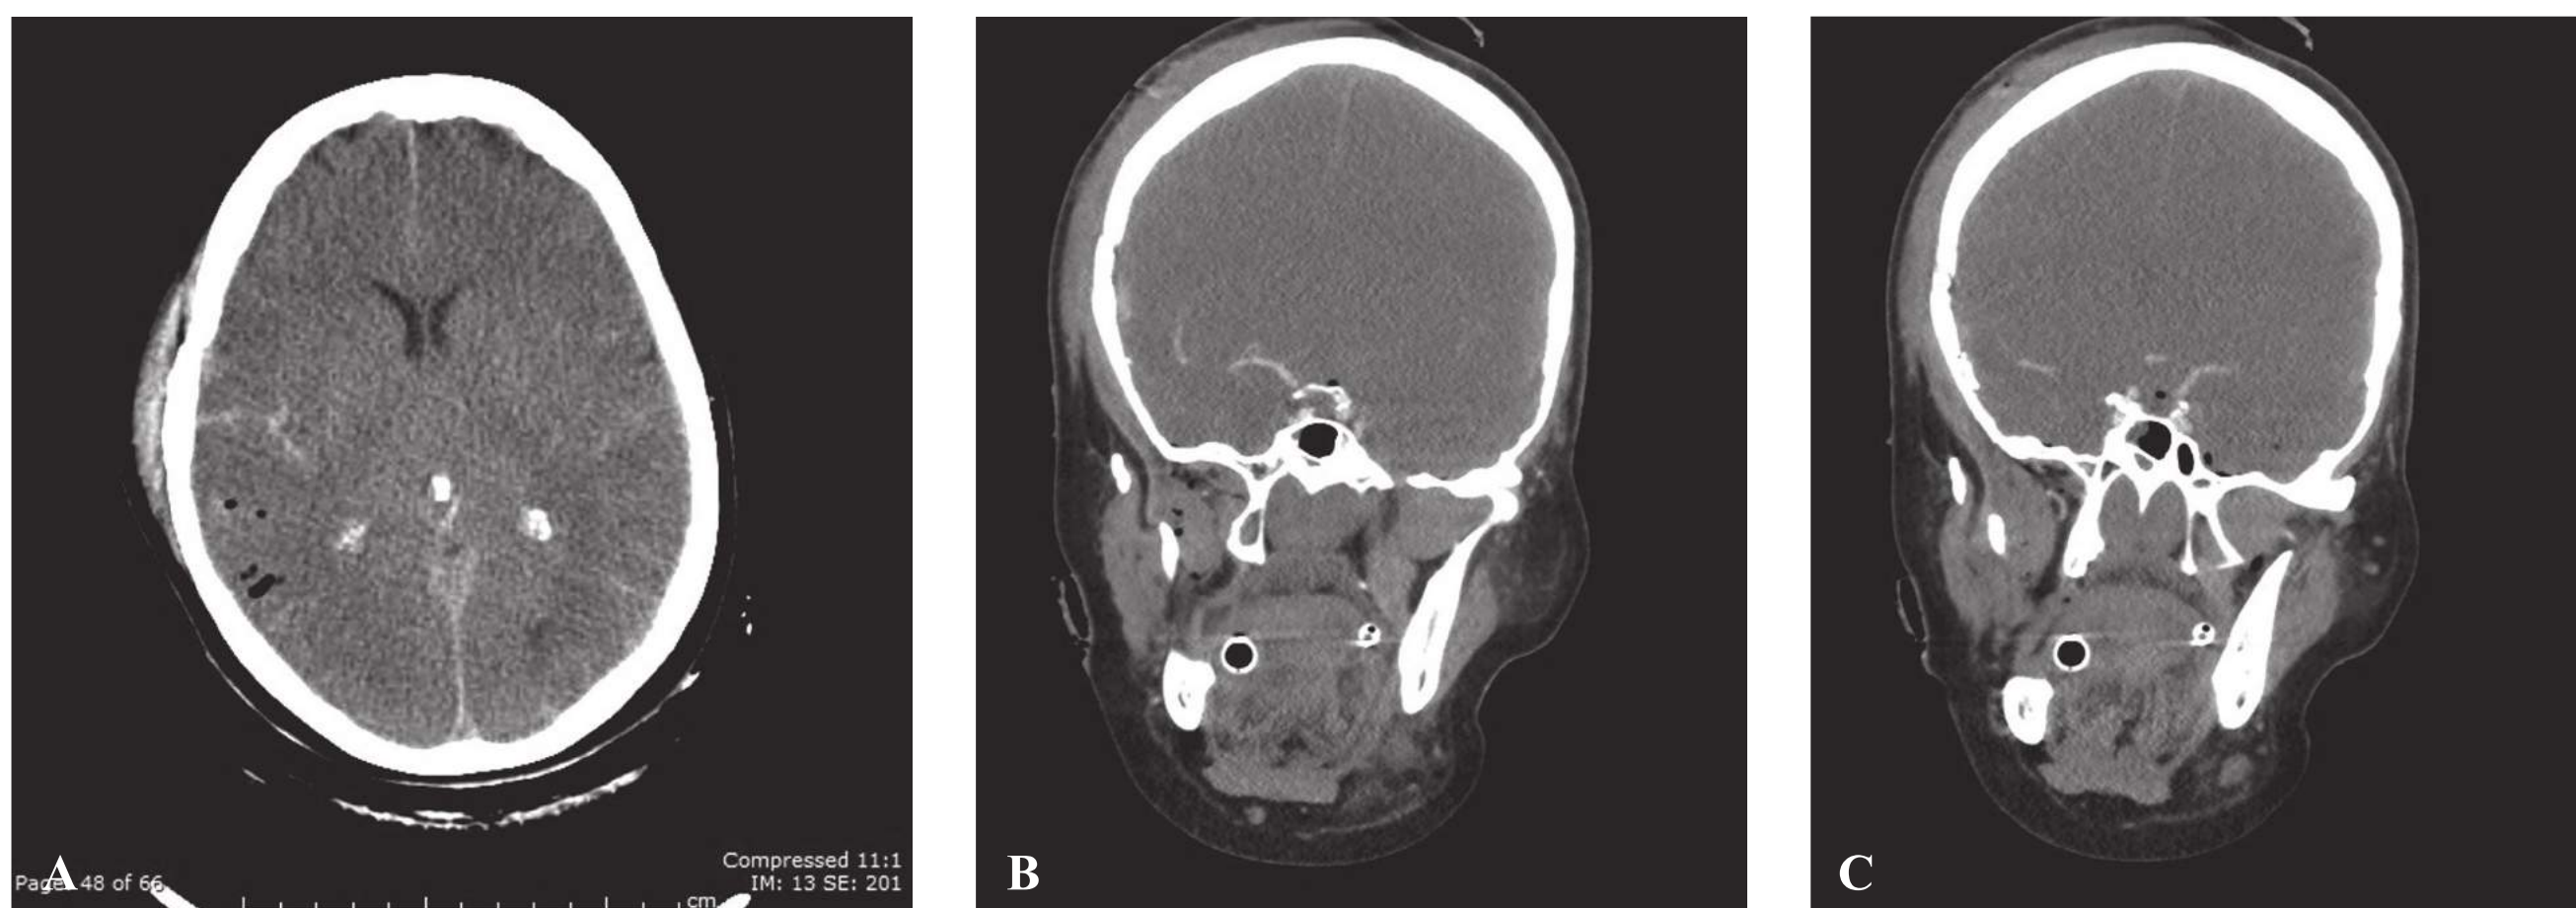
(A-C). CT head and CT angiography. The patient presented after being struck by a motor vehicle. The CT imaging demonstrates diffuse acute subarachnoid hemorrhage involving the basal and suprasellar cisterns, the sylvian fissures, and multiple sulci.
